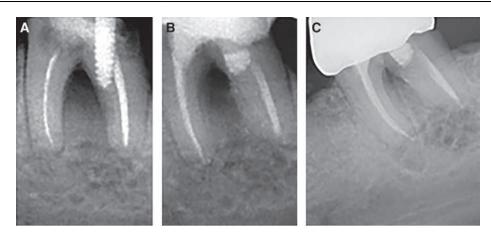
(A) Pre-operativee radiograph. (B) 48 months radiographic follow-up. (C) 48 months radiographic follow-up.
